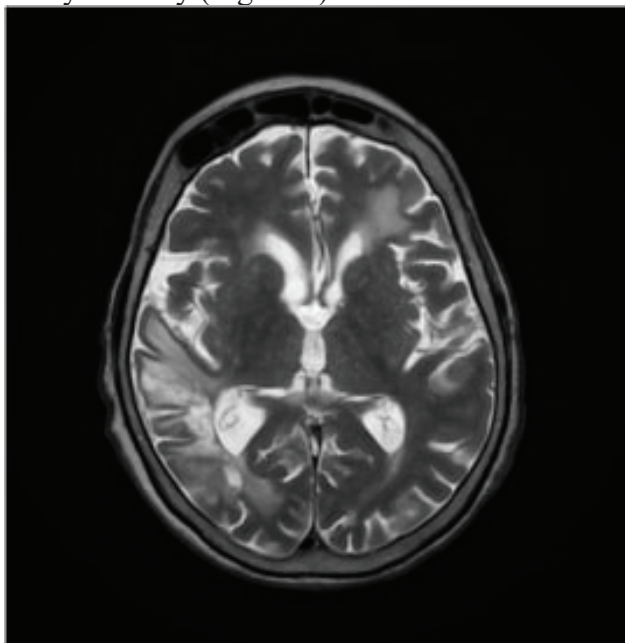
Cranio-encephalic MRI—moderate/high T2 lesion in the left middle cerebral artery territory; high T2 signal lesion with gliosis in the right parietal region.
